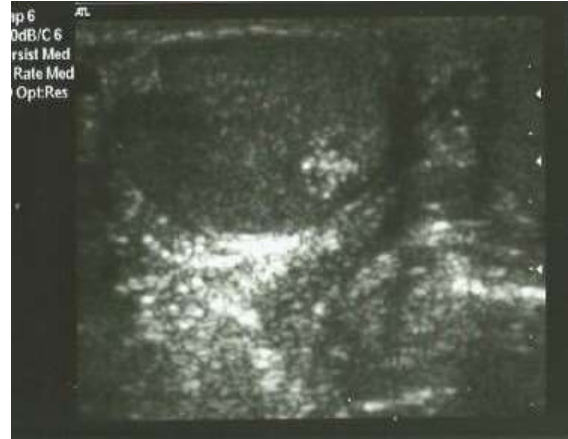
Ultrasonography revealed compromised blood circulation, calcifications and necrotic areas on the testes.
